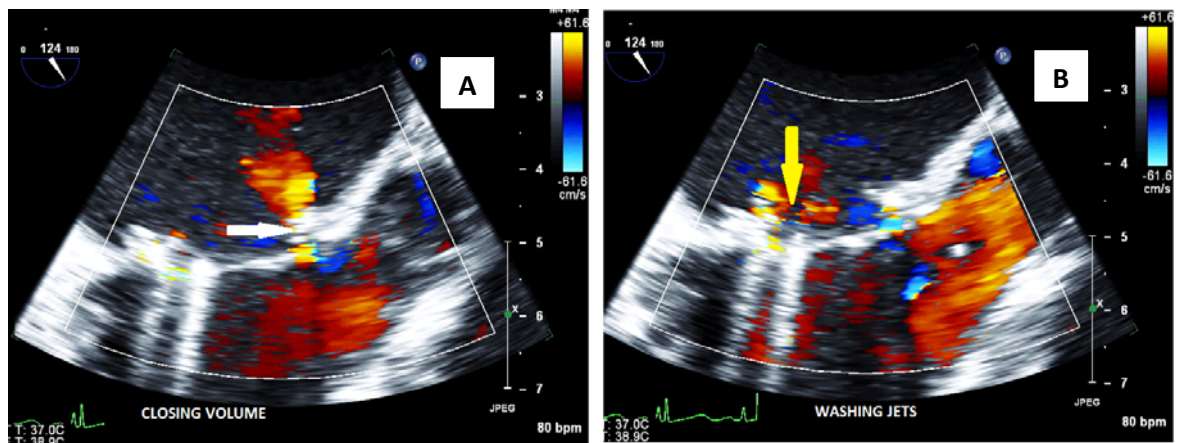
Color Doppler images of CHVP depiction closing volume (A-white arrow) at the contact of tilting disc with annular ring during systole and washing jets (B-yellow arrow) seen at the hinge point. Both the jets are seen inside the valve annulus (intravalvular) and mitral regurgitation is of mild degree.
